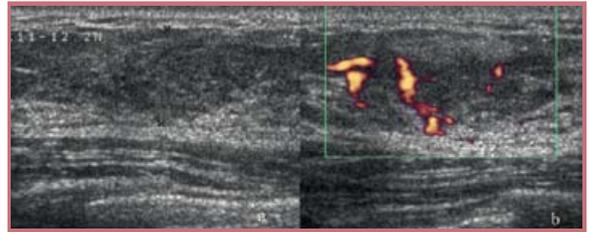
angiosarcoma as ill-defined hypoechoic thickening, b, hypervascularity demonstrated at Power Doppler.
